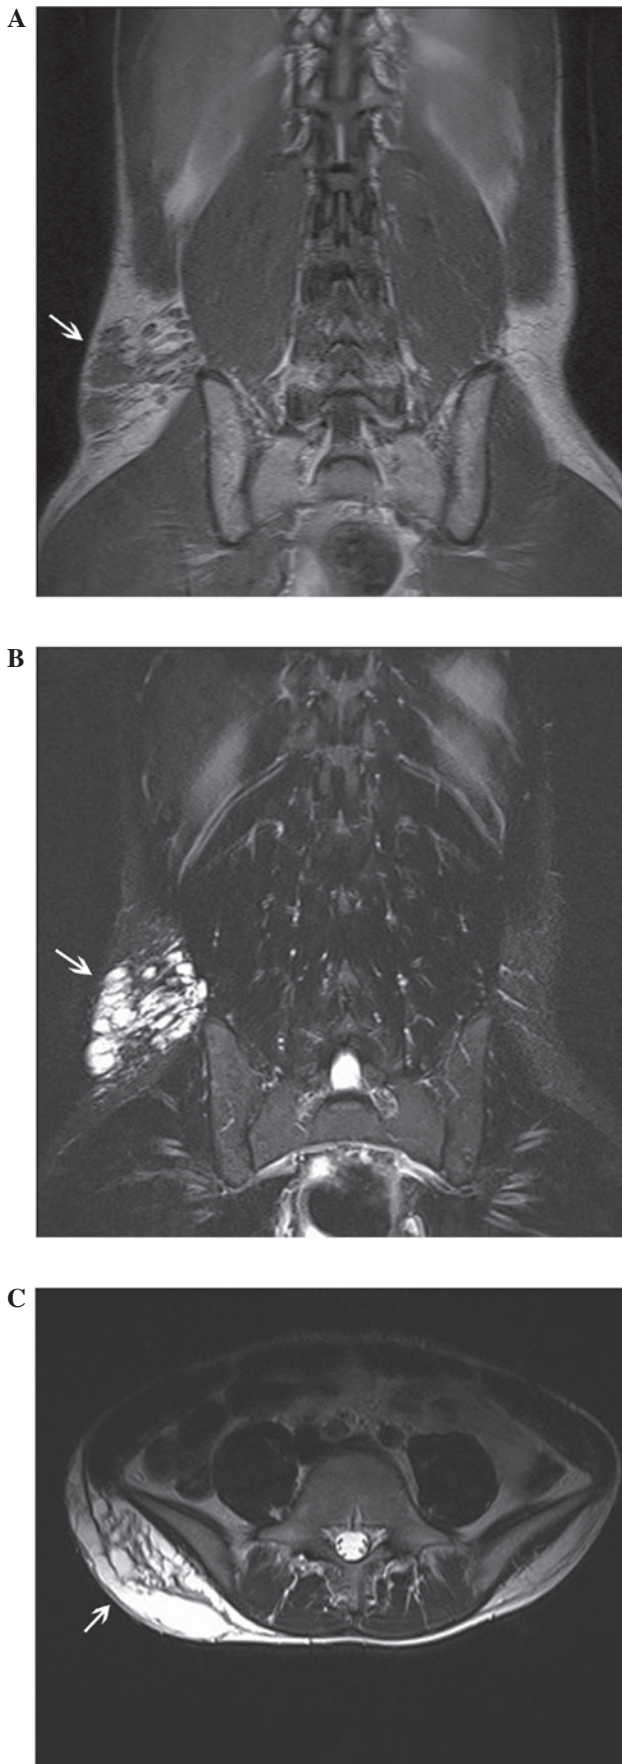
Magnetic resonance imaging (MRI) findings. The scans demonstrate the (A) coronal T1-weighted imaging (WI), (B) coronal T2-WI and (C) axial T2-WI. A mass (arrows) was identified, with low signal intensity on T1-WI and high signal intensity on T2-WI in the right side of the waist subcutaneous tissue with the fifth lumbar level parallel.
